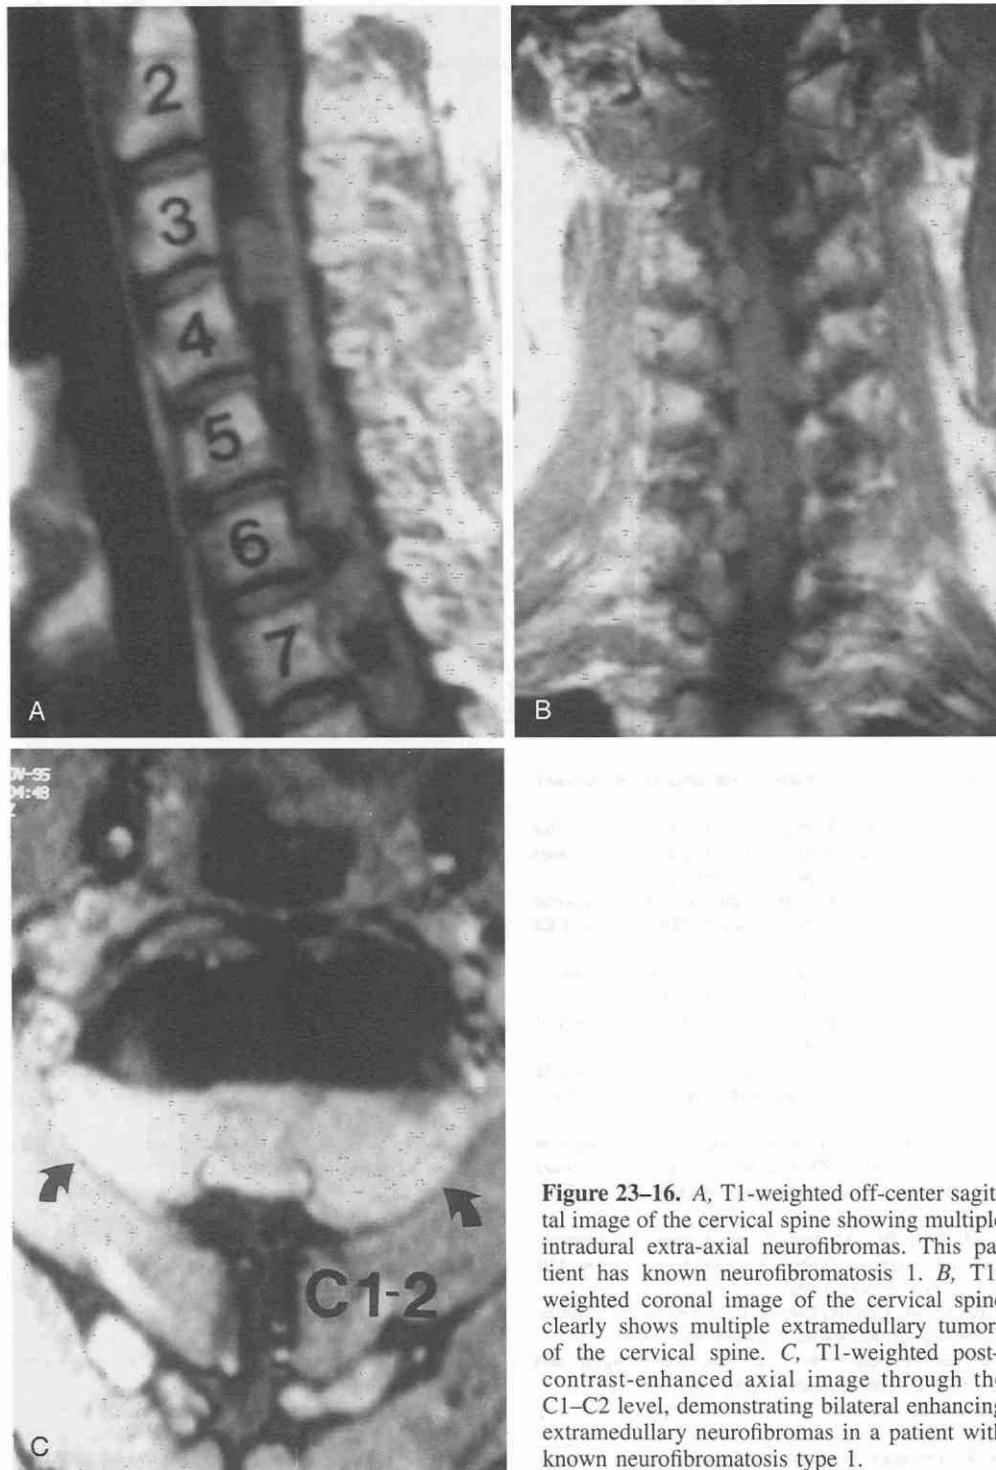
A, T1-weighted off-center sagittal image of the cervical spine showing multiple intradural extra-axial neurofibromas. This patient has known neurofibromatosis 1. B, T1-weighted coronal image of the cervical spine clearly shows multiple extramedullary tumors of the cervical spine. C, T1-weighted post-contrast-enhanced axial image through the C1–C2 level, demonstrating bilateral enhancing extramedullary neurofibromas in a patient with known neurofibromatosis type 1.
